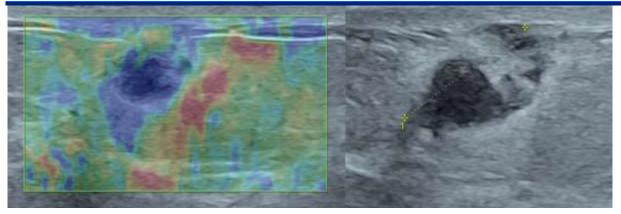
Ultrasound scan shows a very hypoechoic heterogeneous tissue lesion in the superior-external quadrant of the right breast surrounded by a peripheral halo, hard on elastography, classified as ACR4b
